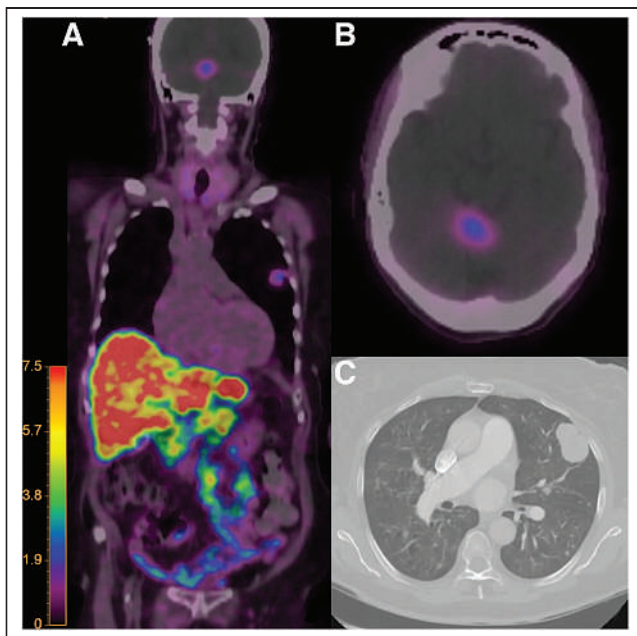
(A) Whole body coronal color fusion map and (B) axial color fusion map ^{68}Ga -DOTATATE PET/CT demonstrate corresponding uptake within the posterior fossa lesion and left lung mass. (C) Chest CT demonstrates the mass in the left upper lobe of the lung. Intensity scale bar in units of SUV.
